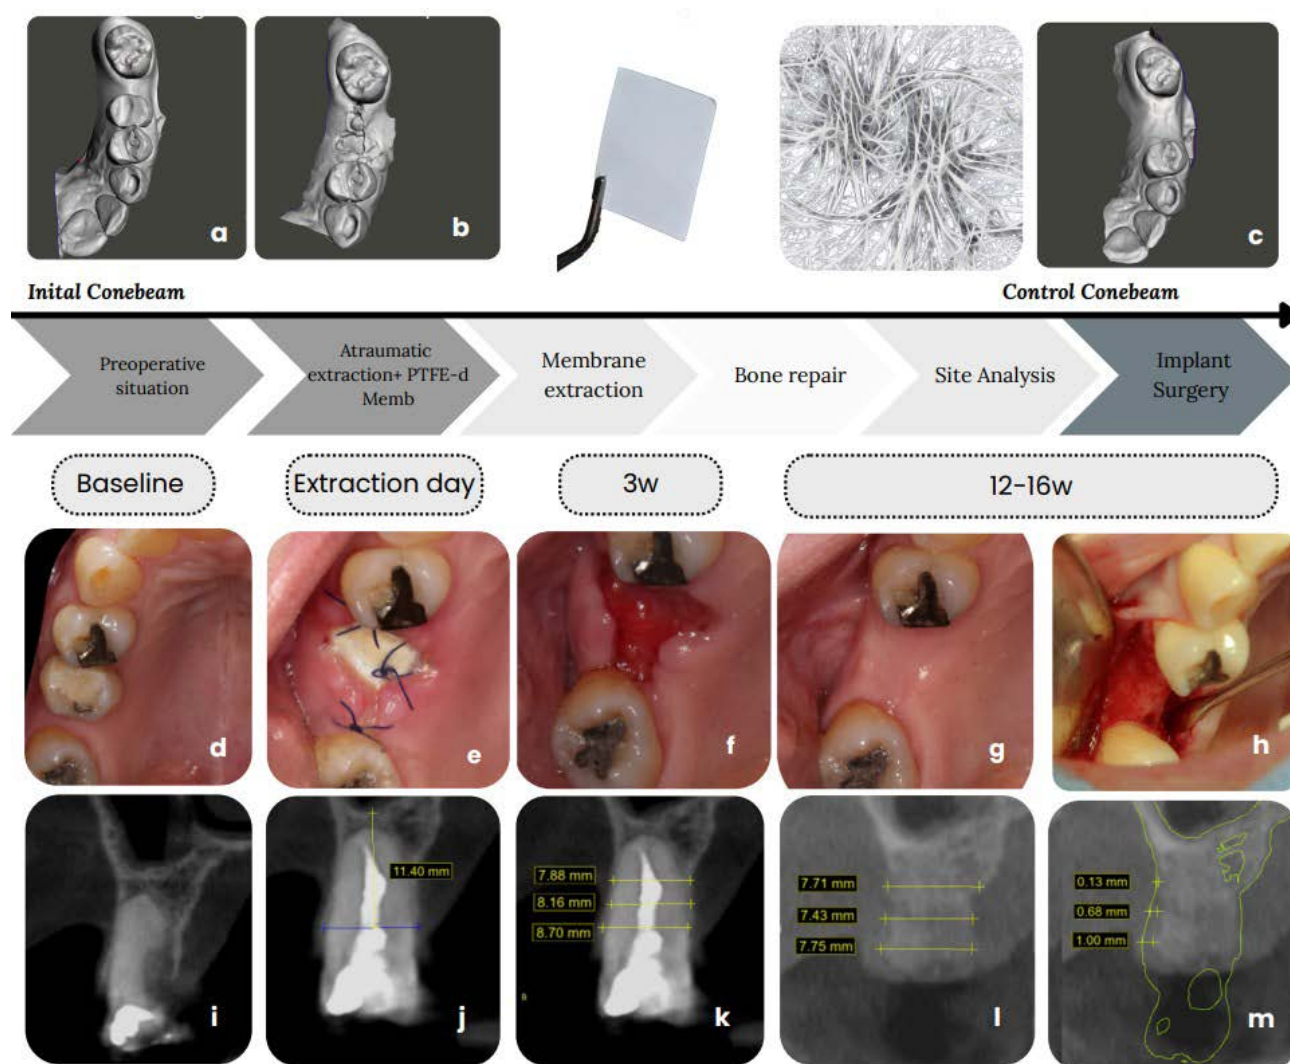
Clinical case follow up: (a) Initial STL scan; (b) STL scan showing placement of PTFE-d membrane; (c) STL scan at 12-week follow-up; (d) Initial intraoral photograph; (e) PTFE-d membrane placement; (f) Membrane removal at 21 days; (g) 12-week follow-up evaluation; (h) Alveolar ridge preserved at 12 weeks; (i) Initial CBCT showing cervical bone wall perforation; (j) Initial vertical bone dimensions on CBCT scan; (k) Initial horizontal bone dimensions on CBCT scan (l) and (m) CBCT at 12-week follow-up post-preservation.
